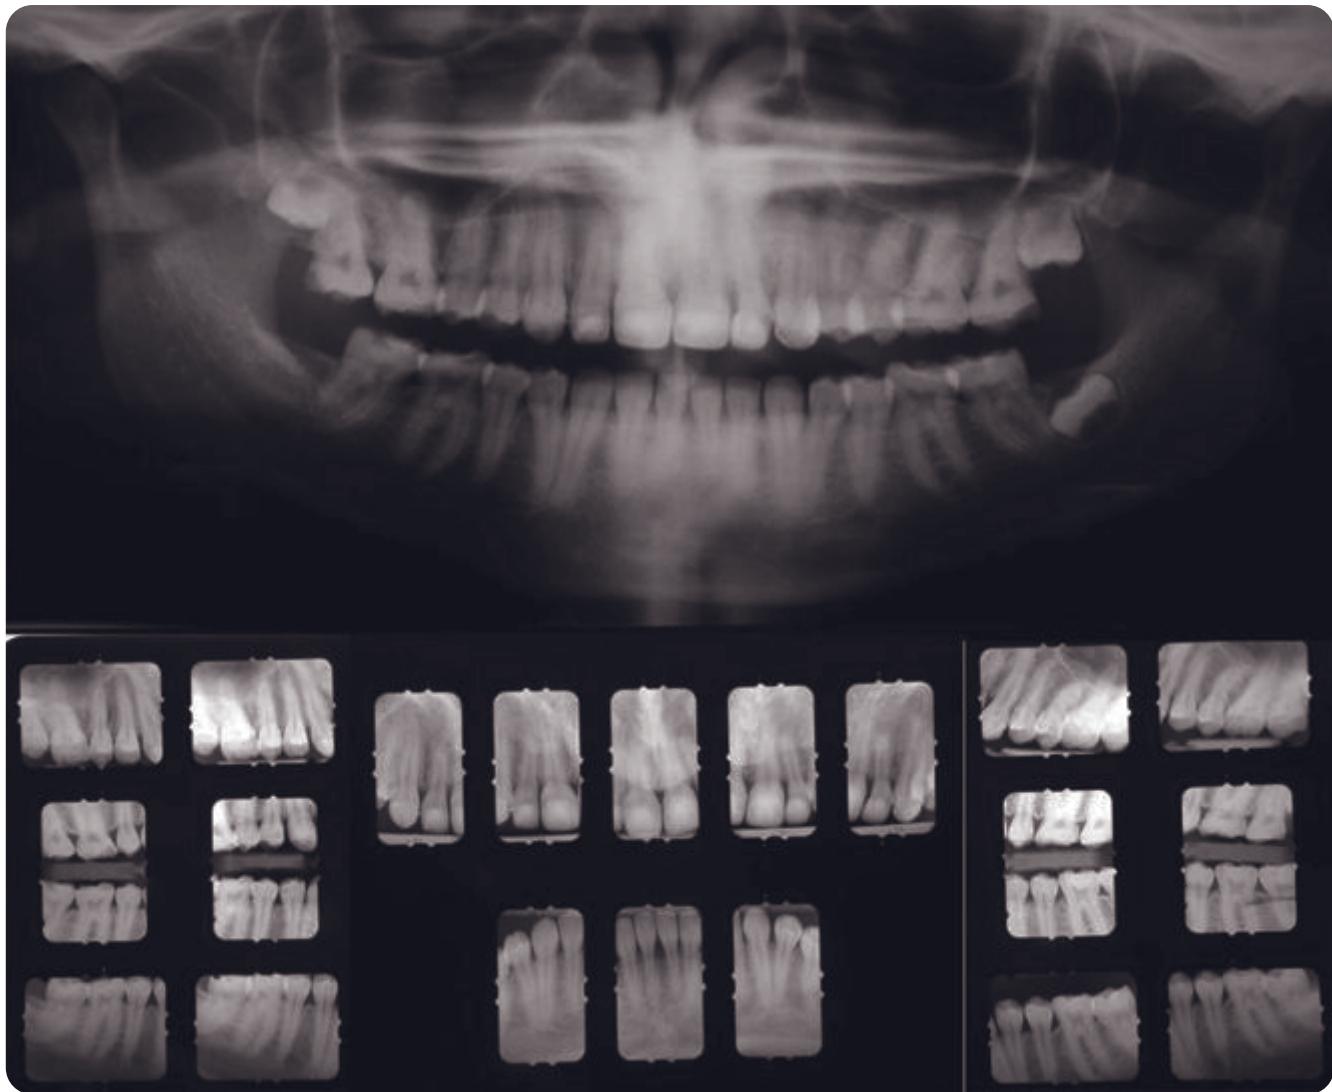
Pretreatment panoramic and periapical radiographs suggesting normal dentin, root anatomy, and bone despite the defective enamel.
